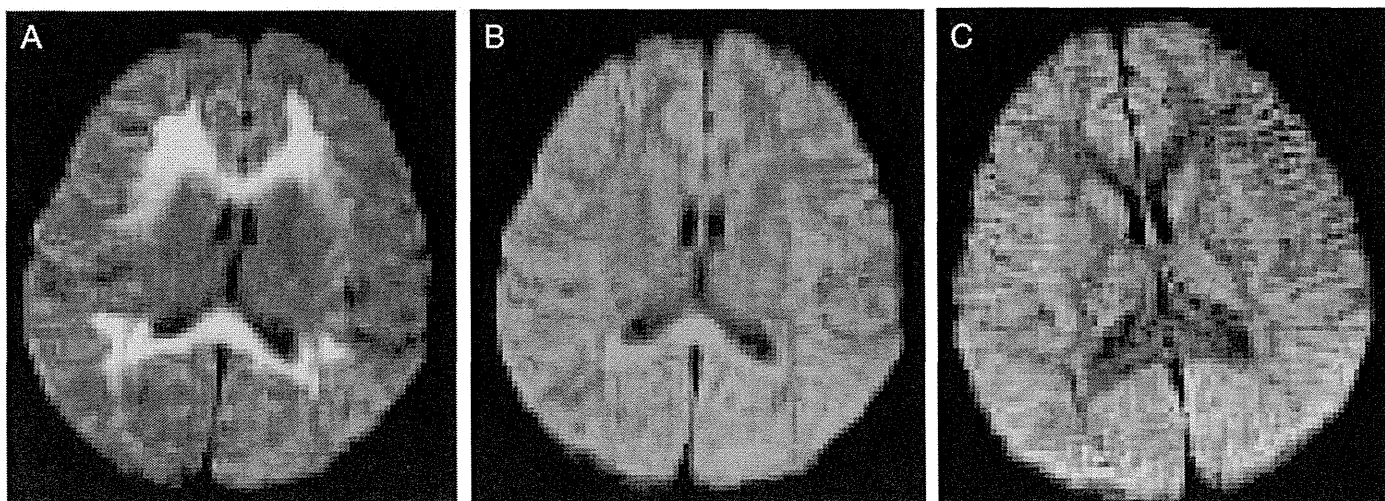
MR imaging of patient 2. MR imaging on admission (day 2) revealed lesions in the diffuse white matter and entire corpus callosum with marked hyperintensity on DWI (A). Second DWI on day 3 showed a markedly hyperintense lesion only in the SCC (B), which had completely resolved on day 6 (C).
